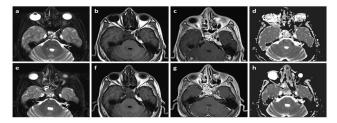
Follow-up MRI in a 39-year-old male with craniopharyngioma showing residual and recurrent lesions.
